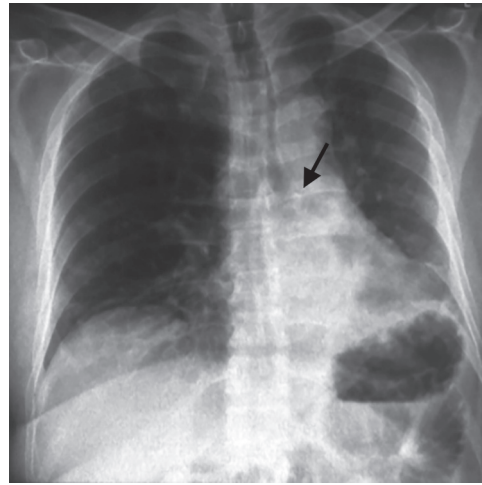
Chest X-ray with the left lower lobe collapse and suspected hyperdense opacity in the left lower lobe bronchus
